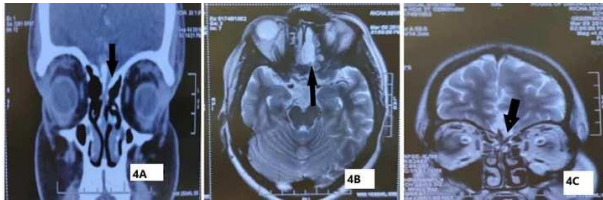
CT Head revealed a well demarcated bone defect in the floor of the anterior cranial fossa involving the cribriform plate on left side (Fig 4A). MRI of brain revealed.
